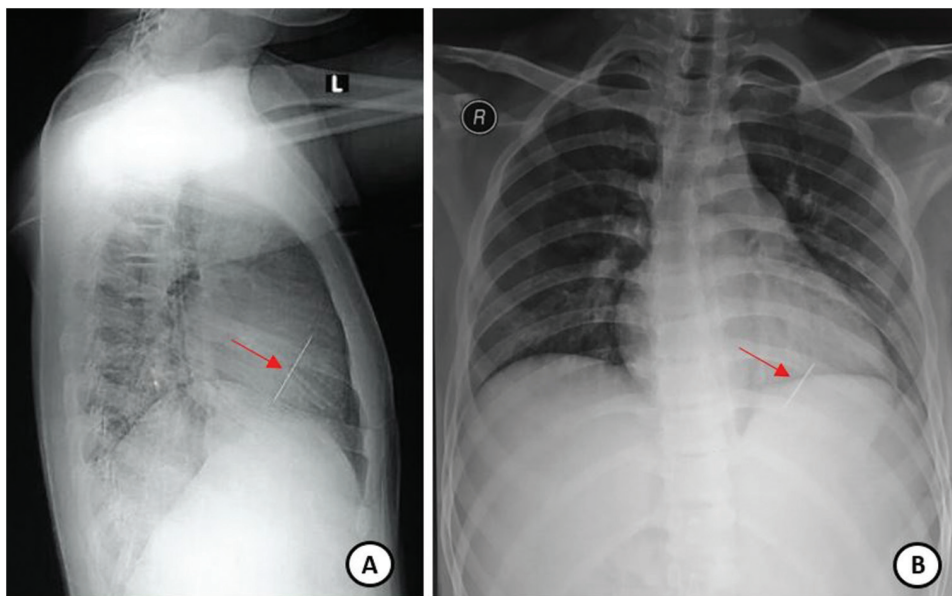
Chest X-ray showing a needle (arrow) in the chest from posteroanterior (A) and lateral projection (B).
